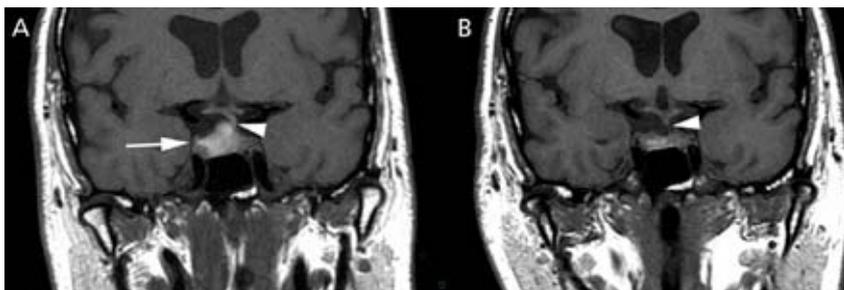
(A) Magnetic resonance (T1 coronal) imaging of the head 11 days after surgery showing a bilobed haemorrhagic intrasellar mass measuring 14×13×12 mm extending into the right cavernous sinus where it impinges on the region of the oculomotor nerve (arrow). (B) Magnetic resonance imaging (T1 coronal) of the pituitary 10 weeks after surgery showing that the high density pituitary lesion had reduced in size to 12×4.5 mm. The pituitary stalk is deviated to the left (arrowheads in parts A and B)
